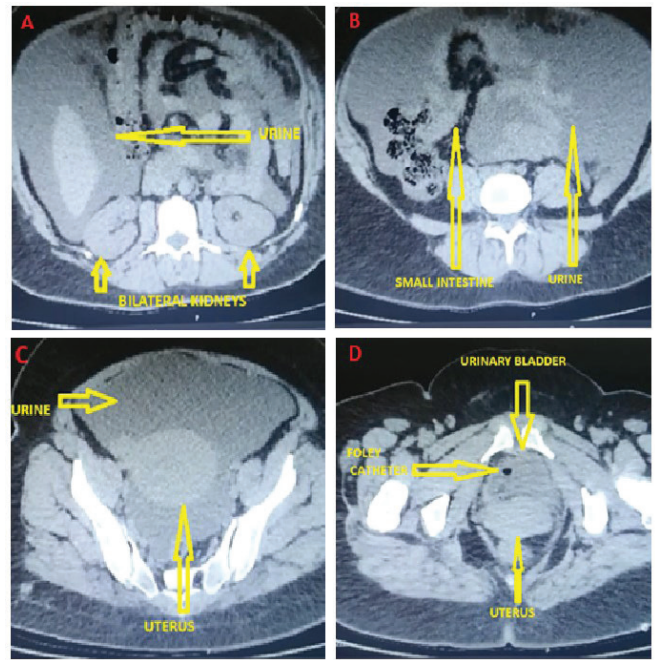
Top-down cross-sectional images of our patient, who was diagnosed with bladder injury after cesarean section, on computed tomography taken after abdominal swelling; A: The appearance of urine extravasation around the kidneys, B: Appearance of widespread urinary extravasation in the abdomen, C: the appearance of urinary extravasation around the uterus, D: Image of traumatized bladder and Foley catheter.
